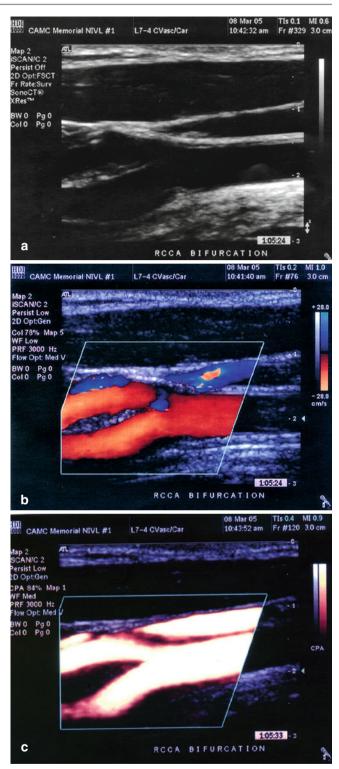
(a) Gray scale of right common carotid artery bifurcation in longitudinal view. (b) Color duplex ultrasound of right common carotid artery bifurcation in longitudinal view. (c) Power Doppler image of right common carotid artery bifurcation in longitudinal view
